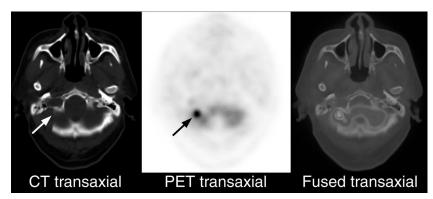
The fused FDG PET/CT images of the delayed-phase scan revealed that the focal intense FDG radioactivity (black arrow) was at the edge of the bone defect (white arrow) caused by the previous operation. Residual malignancy was highly suspected. The subsequent biopsy of this area proved the presence of residual osteosarcoma. Previous studies have suggested the potential uses of FDG PET for osteosarcoma, including staging and grading of the tumor, ^{1–3} monitoring the neoadjuvant therapy response, ^{4–6} and differentiating viable sarcoma from post-treatment changes.^{7,8} Many authors have proposed to use dual time point scene to differentiate mellionet and because the different dual-time point scans to differentiate malignant and benign lesions because the FDG uptake of a malignant lesion tends to reach its peak several hours later, but the time to peak radioactivity of a benign lesion is usually within an hour.^{2,9,10} Previous studies^{11,12} have described the usefulness of routine FDG PET scan without mention of delayed-phase images to detect skull malignancies and giant cell tumor, because of the sufficient high contrast between the tumors and physiological tissues in their reports. However, unlike our case that seems concealed by the adjacent high physiological brain activity, the lesions in their reports have characteristic protruding radioactivity beyond the brain tissue, which may be a more important feature to recognize these lesions. On the contrary, the lesion in our case was only recognizable on the delayed-phase images. However, because the lesion site is directly related to the prior tumor, this finding still prompts subsequent proof of malignancy via biopsy. Although we have carefully reviewed the corresponding area in the early phase scan, we still cannot find a suspicious abnormality that can be confidently interpreted as malignancy. The reason why we can only note the lesion on the delayedphase scan is possibly due to a combined effect of the interference of the adjacent abundant brain activity and the limited spatial resolution of the PET scan for such a tiny lesion. Finally, this case again emphasizes the importance and usefulness to use an additional delayed-phase FDG PET scan to enhance the detectability for the survey of cancers, even though the lesion may be "invisible" in the early phase scan.
